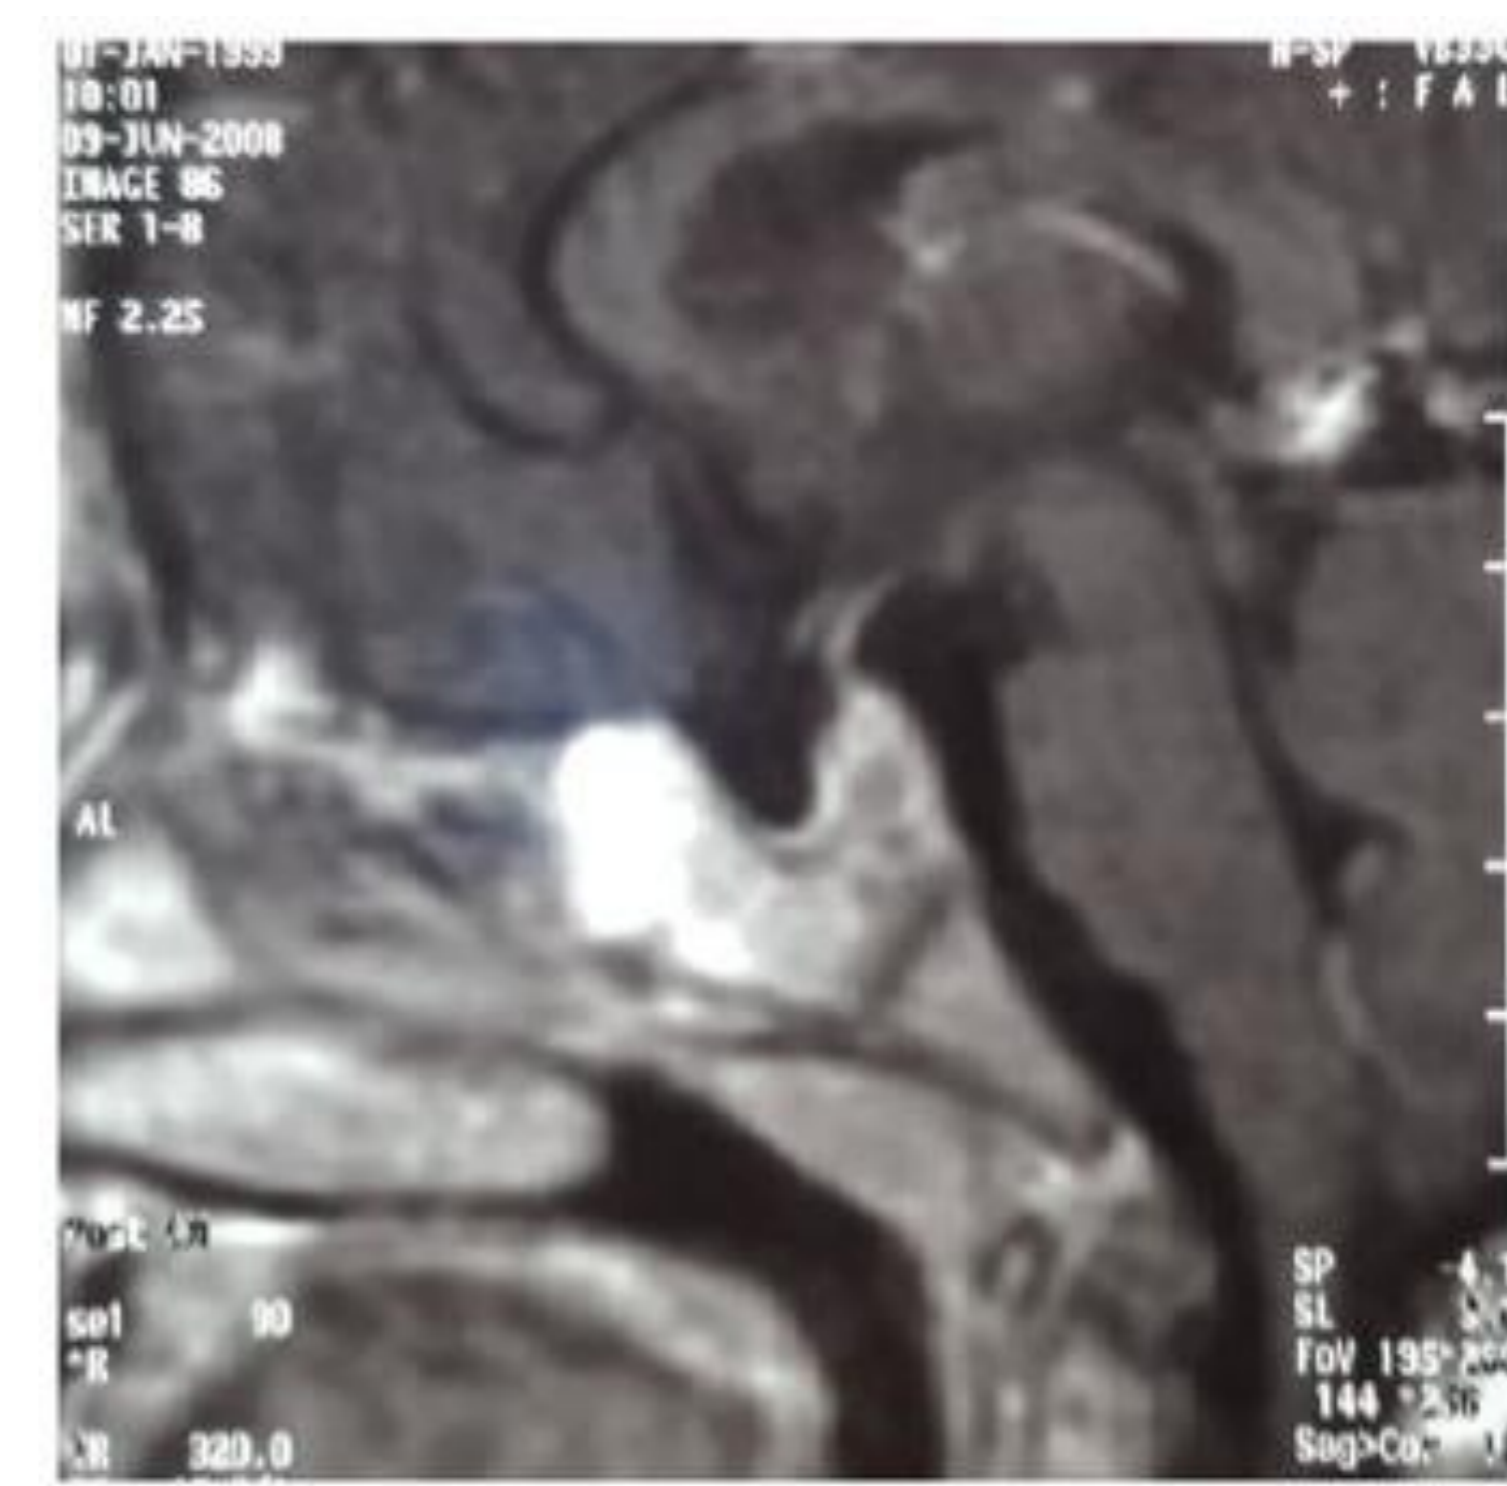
Follow up MRI of the sella 10 months after treatment. The pituitary gland is normal in size and configuration, remains confined to the sella, and shows homogeneous enhancement.
